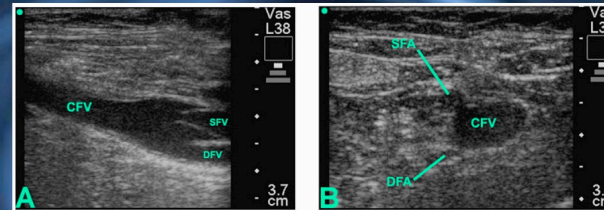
Long- (A) and short- (B) axis ultrasound images of vascular elements at representative portions of the proximal lower extremity. The venous structures were initially collapsed, and not sonographically evident until filled by injection from above. [Key: CFV = common femoral vein, SFV = superficial femoral vein, SFA = superficial femoral artery, DFA = deep femoral artery]
